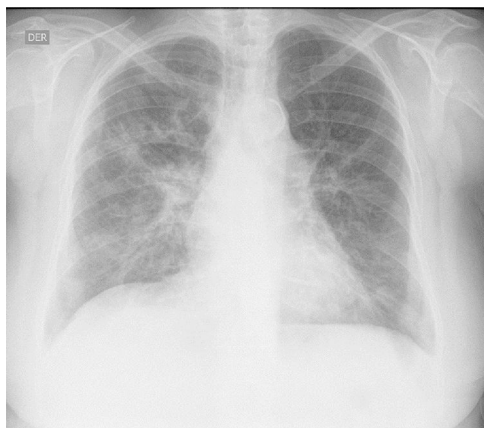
Chest X-ray. Bilateral parahilar and basal alveolo-interstitial opacities with a reticular predominance are observed.
